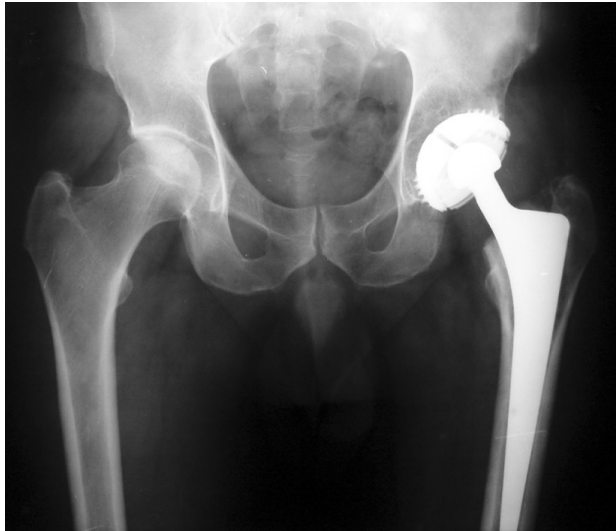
Postoperative control X-ray image of case 51 (table 5) with 18 years of follow-up
